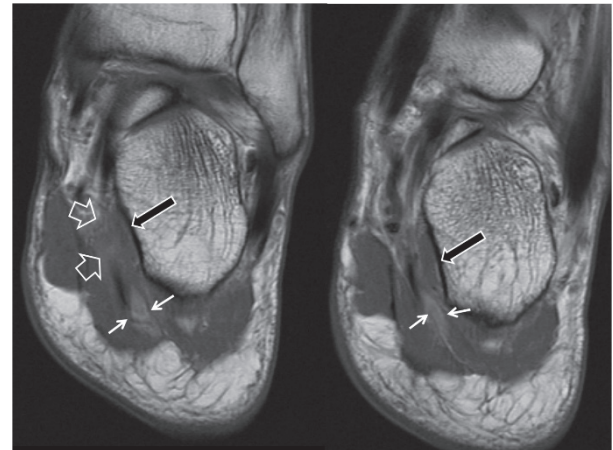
Consecutive T1-w MR images showing the swollen quadratus plantae muscle (thick and open arrows) and the high signal intensity of the lateral plantar vein (thin arrows) in keeping with clinically occult thrombosis.
